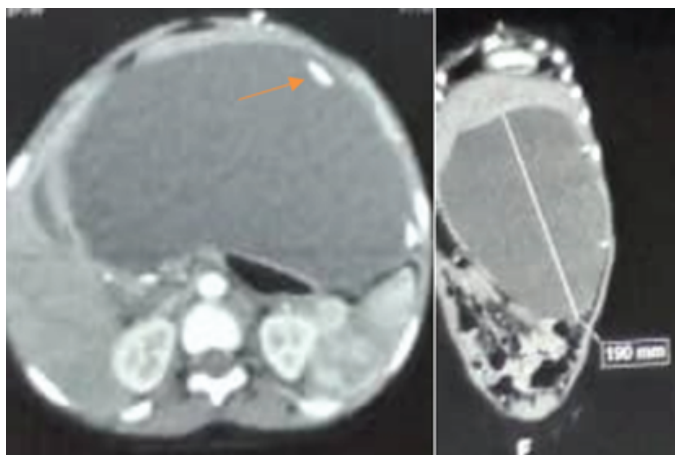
Abdominal CT scan axial cut on the right and sagittal reconstruction on the left: showing a large pseudocystic abdominal CSF with a drain in place (arrow)
